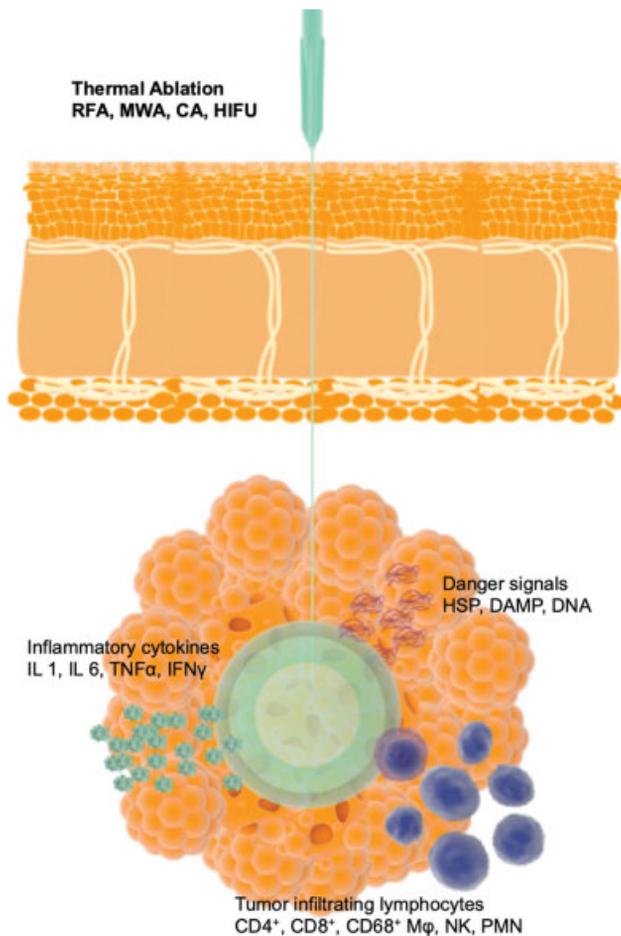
A general depiction of the cellular disruption and immunostimulation that results from the various forms of thermal ablation. Abbreviations: CA, cryoablation; DAMP, damage-associated molecular protein; DNA, deoxyribonucleic acid; HIFU, high-intensity focused ultrasound; HSP, heat shock protein; IFN- γ , interferon gamma; IL-6, interleukin 6; MWA, microwave ablation; NK, natural killer; RFA, radio frequency ablation; TNF- α , tumor necrosis factor alpha.
